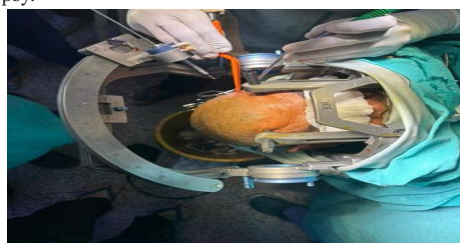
Intraoperative photograph showing the stereotactic arc and trajectory guide mounted on the head frame during CT-guided biopsy.
